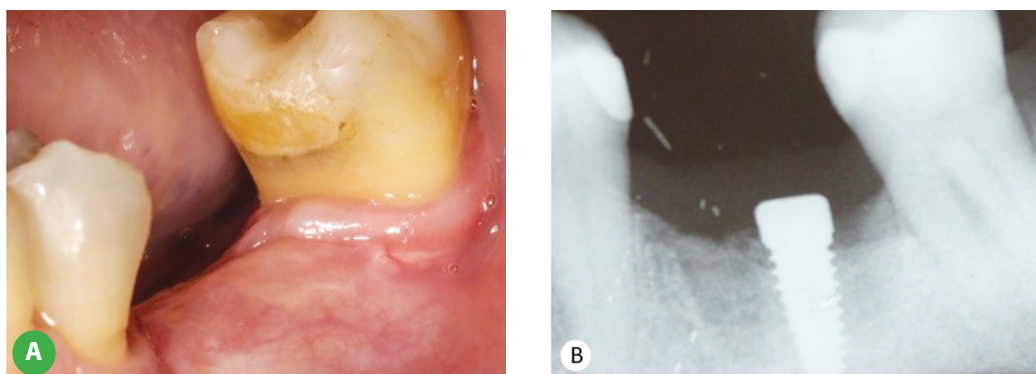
Clinical aspect 5 months after implant placement (A). Radiographic image after implant placement, indicating osseointegration and no bone loss (B).
